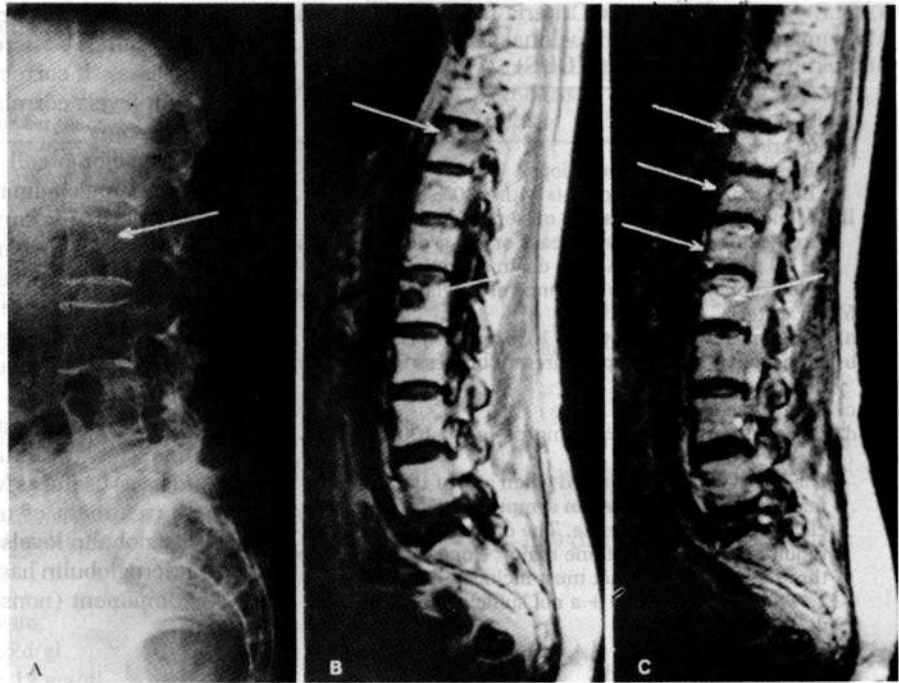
(A) Radiograph of lower spine compared with (B, C) magnetic resonance images. The osteolytic lesions in the vertebral bodies of T10-12 and L1 that were poorly visualized on plain films were much more visible on the (B) T1-weighted and (C) T2-weighted MR images. (Ludwig M, Tscholakoff D, Neuhold A, et al. Magnetic resonance imaging of the spine in multiple melanoma. *Lancet* 1987;2:364-366)
